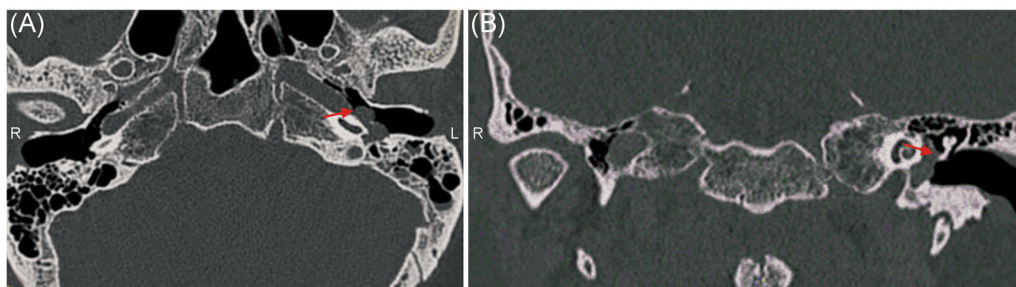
Computed tomography (CT) scan of temporal bone showing glomus tympanicum involving hypotympanum. (A) In axial section, showing the mass occupying left middle ear (indicated by red arrow); (B) In coronal section showing mass medial to the malleus handle and involving the hypotympanum of left ear (indicated by red arrow).
